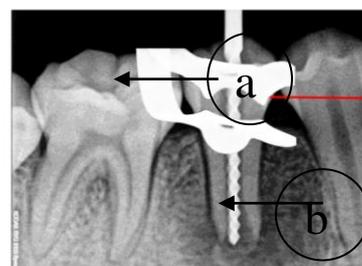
Estimation of Working length in 35 with the help of intraoral periapical radiograph(IOPA)
